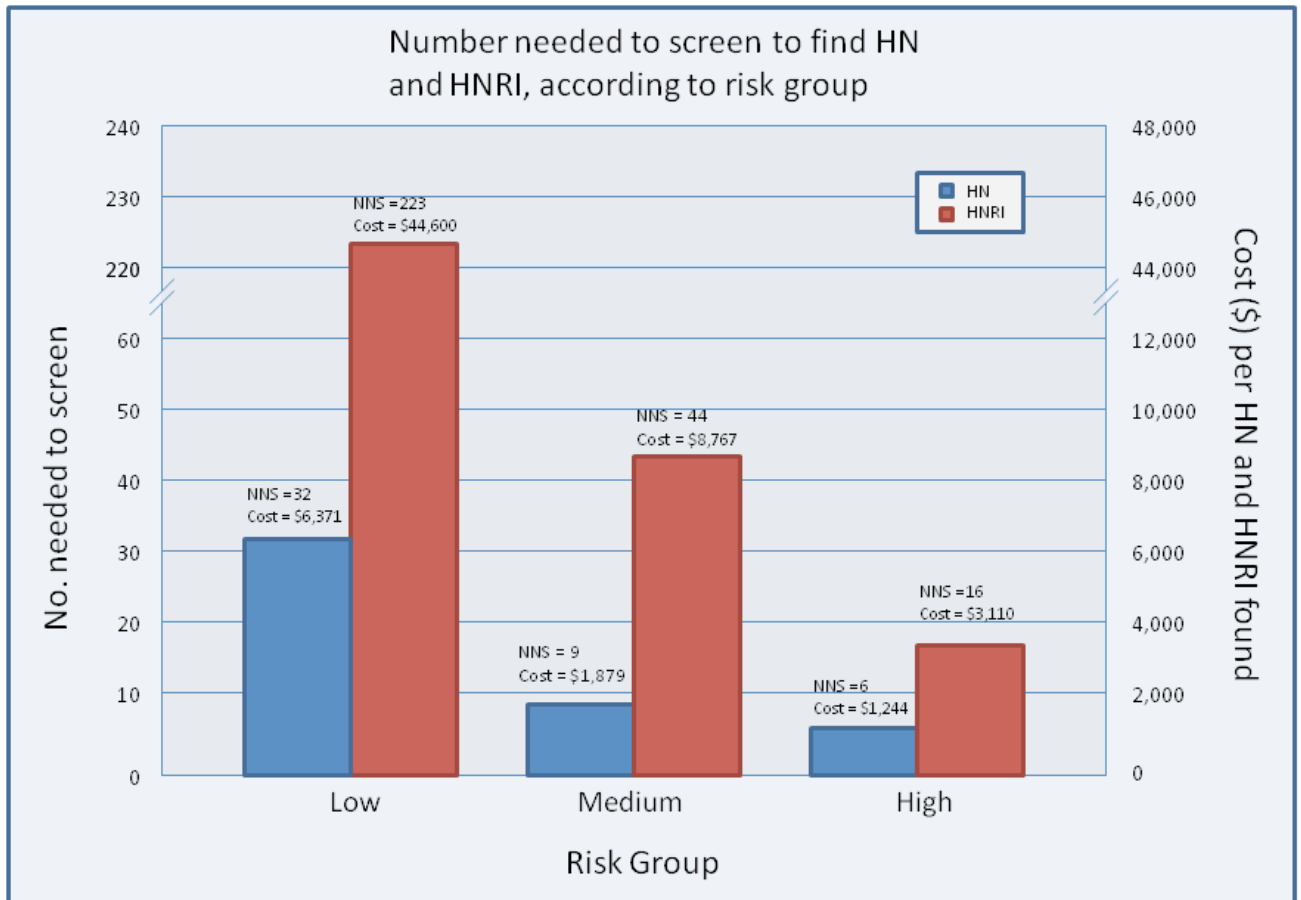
Number needed to screen (NNS) and cost per positive result of renal ultrasound evaluation, according to risk group. NNS = number of outcome events (HN or HNRI) / number of patients risk group. Cost = NNS (HN or HNRI) x \$200 (approximate cost of ultrasound study).
